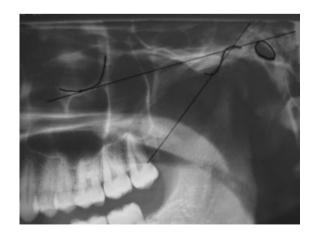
Horizontal reference line marked in panoramic radiograph.
